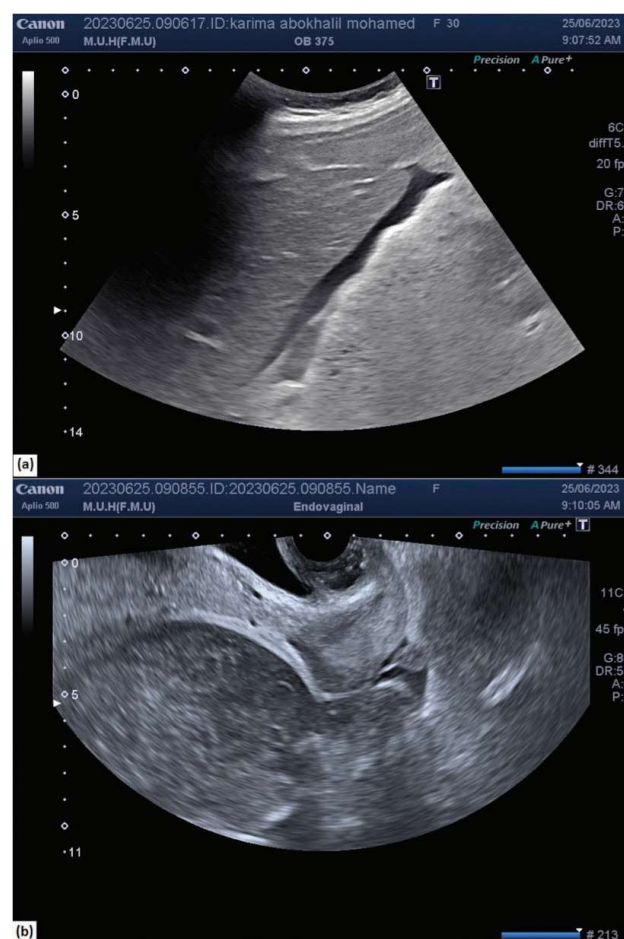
Ultrasonographic diagnosis of hemoperitoneum in patient number 5 through presence of free fluid in hepatorenal gutter by transabdominal sonography (a) and presence of free fluid in Douglas Pouch by transvaginal sonography (b).
